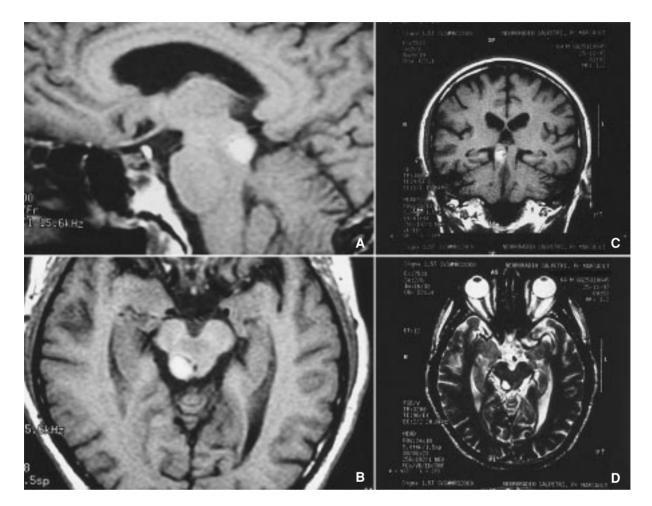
Sagittal (A), axial (B) and coronal (C) T1-weighted gadolinium-enhanced and sagittal T2-weighted (D) MRI showing a right inferior collicular cavernoma without extension to the surface of the brain stem
